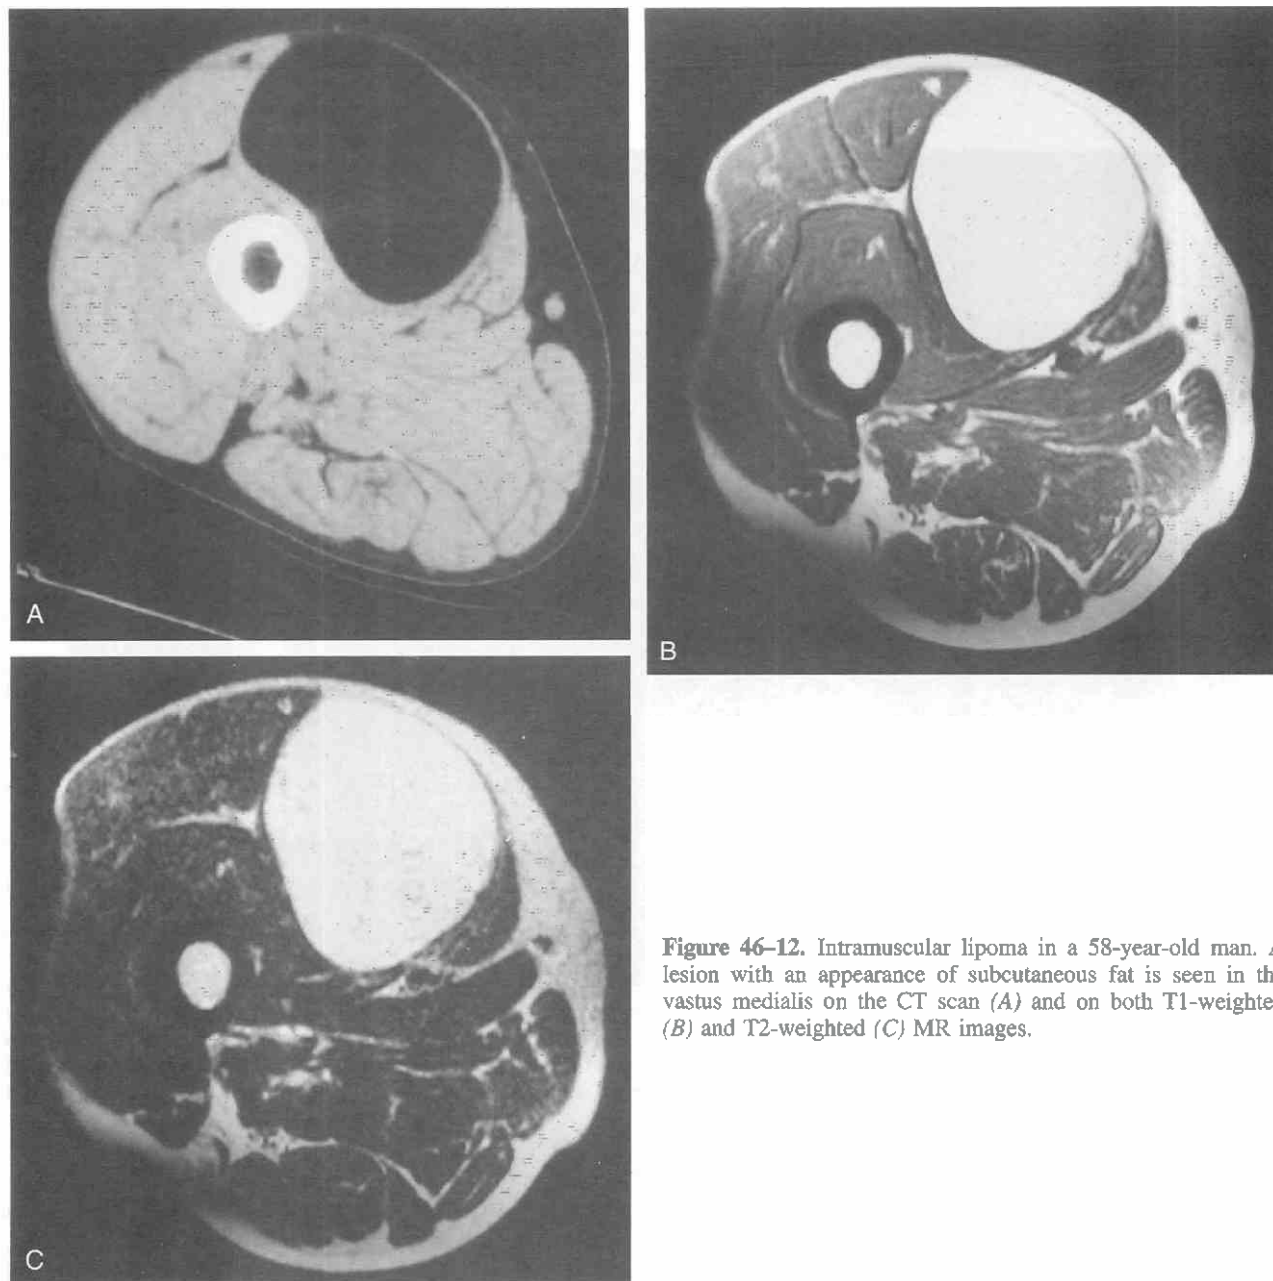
Intramuscular lipoma in a 58-year-old man. A lesion with an appearance of subcutaneous fat is seen in the vastus medialis on the CT scan (A) and on both T1-weighted (B) and T2-weighted (C) MR images.
